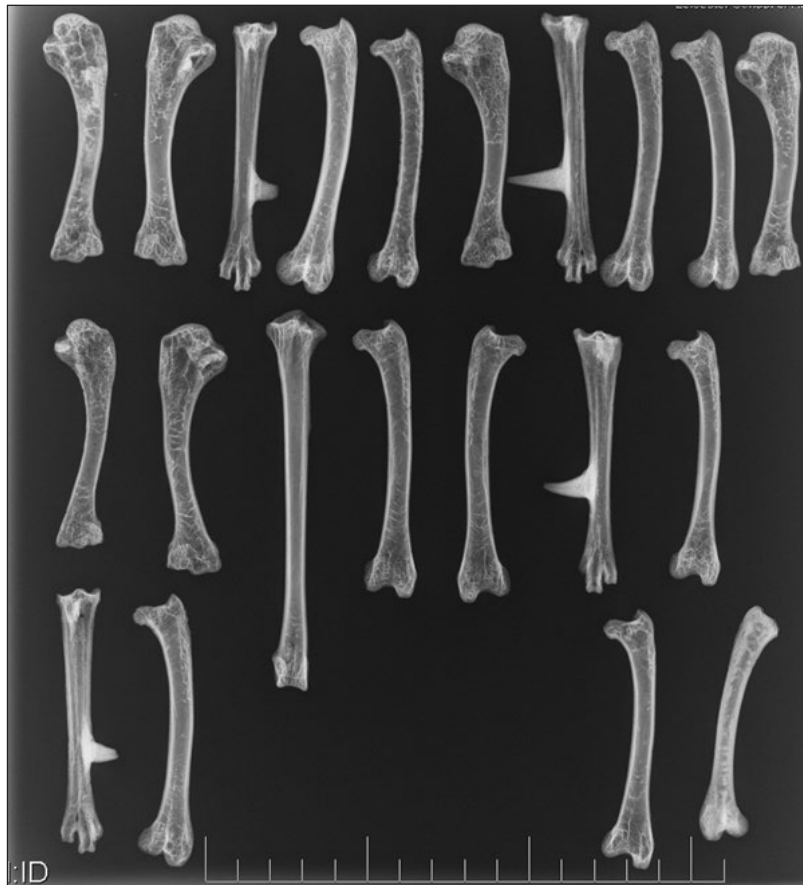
A selection of femora, tibiotarsi and tarsometatarsi from Uley. Humeri are also included in this x-ray for bone density comparisons. The bottom right femur displays a thin layer of medullary bone.
